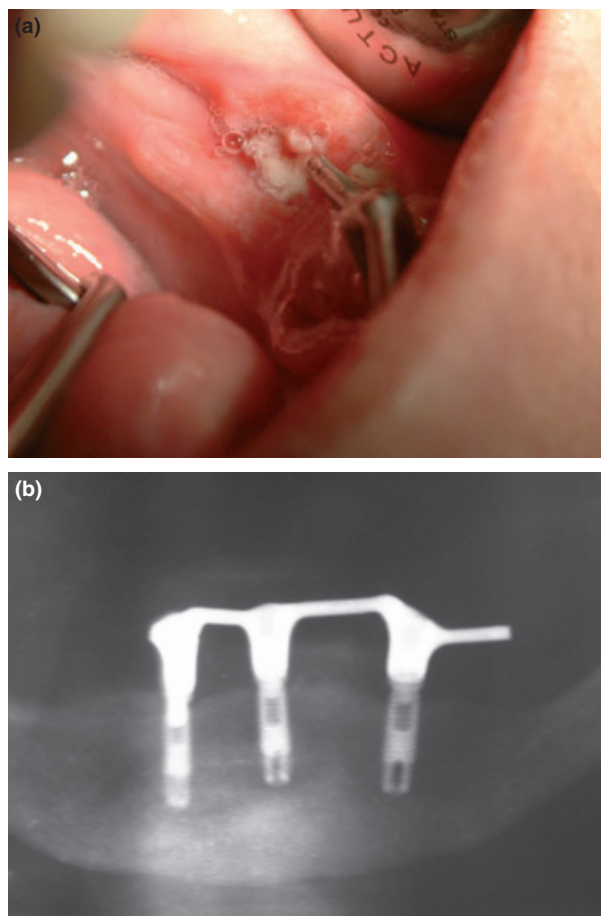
(a) – Image of the ulcerous lesion and distal extension of the cantilevered bar. (b) – Panoramic radiograph showing a three-implant-supported milled connecting bar with left posterior cantilever.
